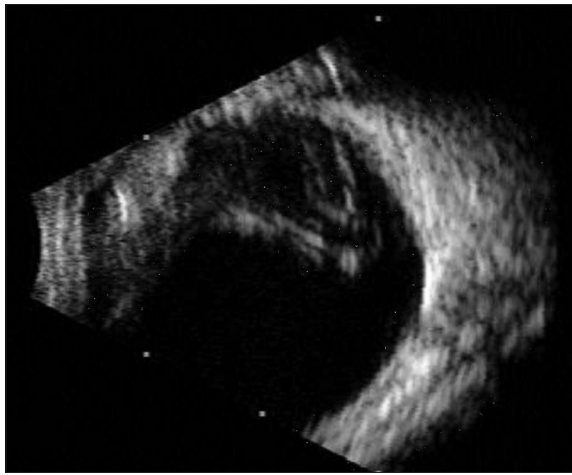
Ultrasound shows vitreous detachment; axial length is 31.5 mm. In the presence of media opacity, ultrasound helps rule out intraocular mass lesion
